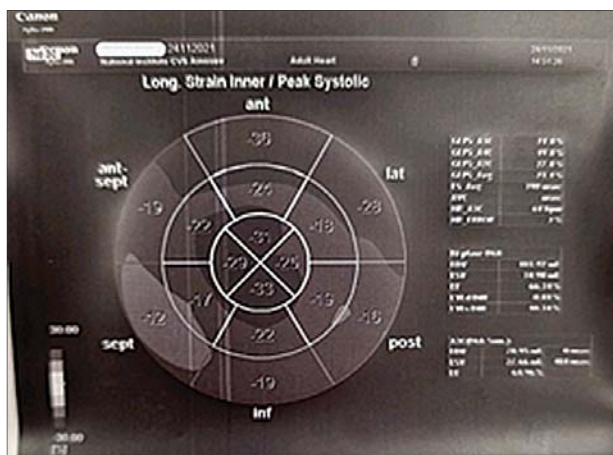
Result of 10 mg dobutamine stress echocardiography (after LMCA stent placement)
